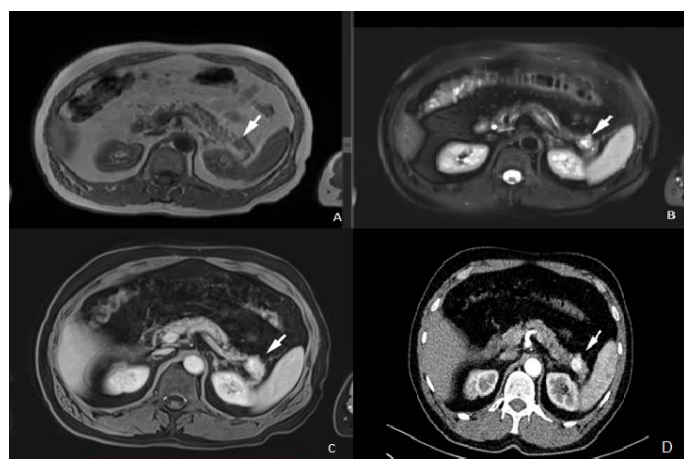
Different imaging modalities that point the lesion. (A) MRI-T1 reveals oval lesion in pancreatic tail, shows predominantly low signal intensity (white arrow). (B) High signal on fat-suppressed T2-weighted image (white arrow). (C) MRI T1 with contrast: Same lesion with typical enhancement on post-contrast T1 (white arrow). (D) CT contrast enhanced: Well defined pancreatic tail focal lesion, presents homogenous arterial enhancement (white arrow).
